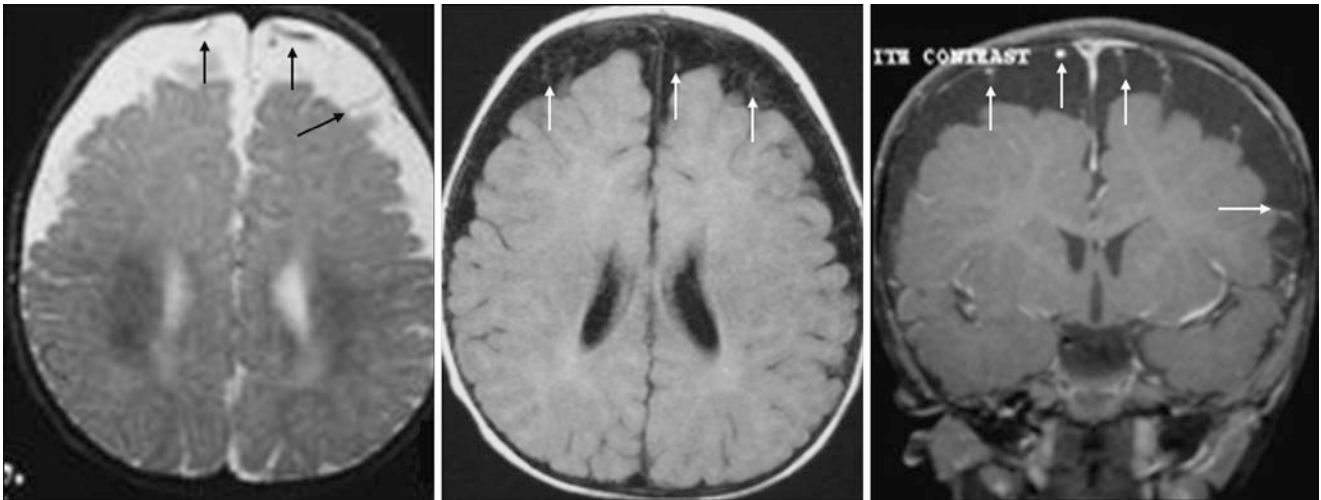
A developmentally normal 10-month-old with macrocephaly underwent a 1.5T MRI. The SAs were moderately enlarged along the frontal convexities, and were crossed by multiple small
